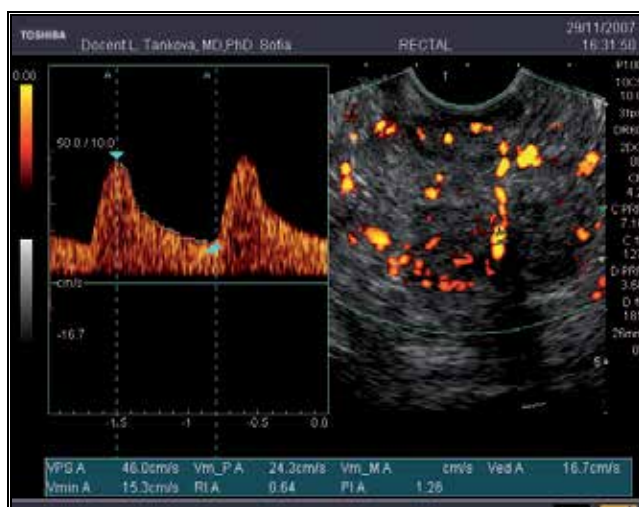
Power Doppler endosonography of rectal cancer with high vascularisation - abundant chaotic vascularisation in the centre and periphery of the tumour (high PSV - 46 cm/s and low RI - 0.64)
